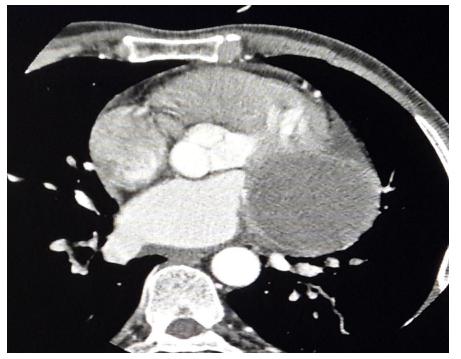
Axial CT images of 45 years old male showing a large thrombosed aneurysm in left pericardial region. It is abutting the left atrial and left ventricular walls
